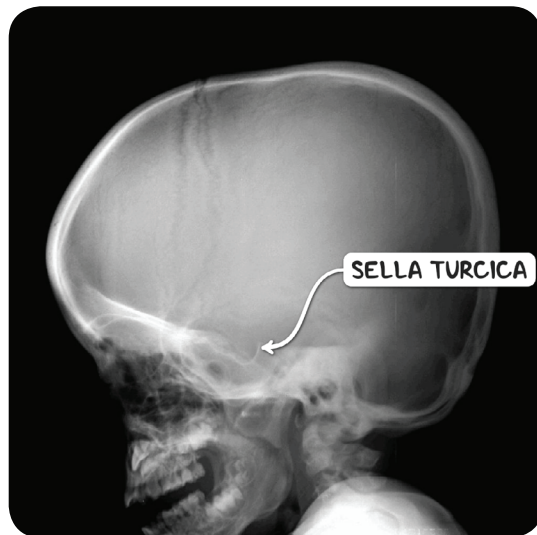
An X-ray image of the head of an infant with Hurler syndrome, showing a J-shaped sella turcica.
